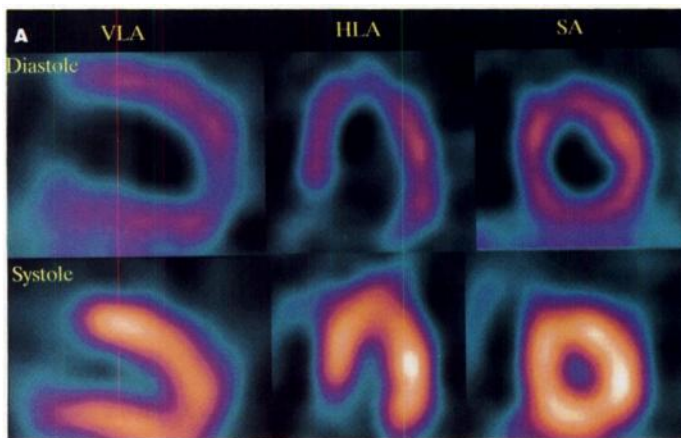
Gated ^{99m}Tc -tetrofosmin SPECT (A) and cine MRI (B) of left ventricle of a 69-yr-old woman presenting with a history of exertional chest pain. Perfusion and contractility were normal. VLA = vertical long-axis; HLA = horizontal long-axis; SA = short-axis.
